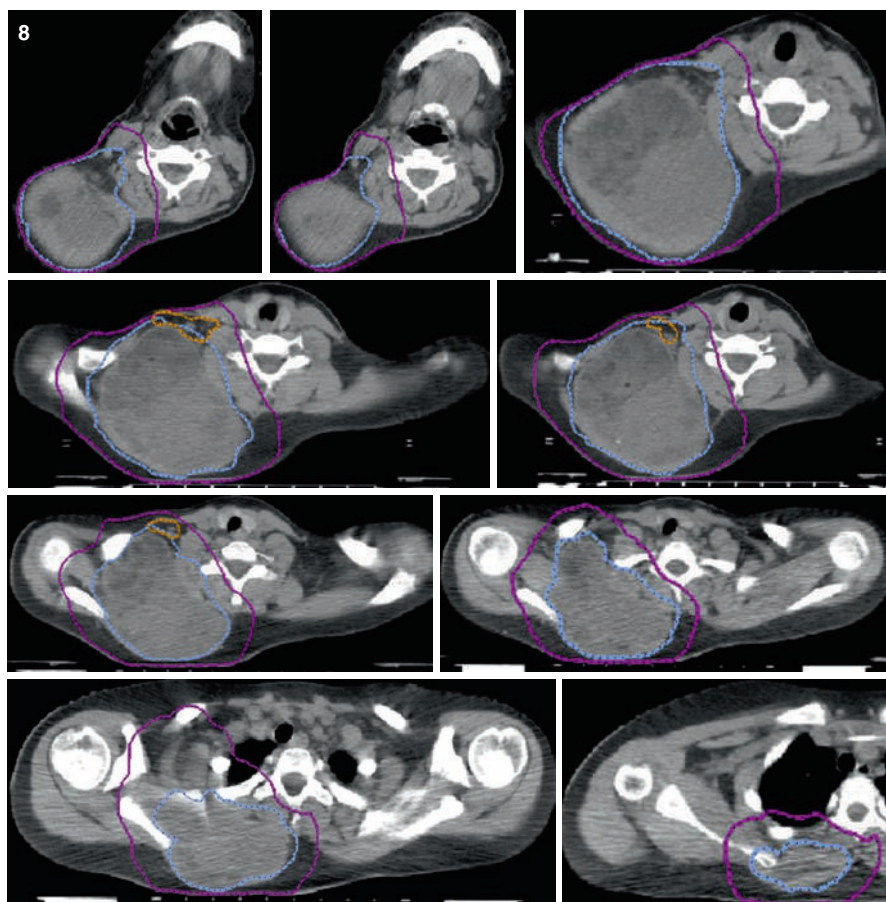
Contouring the GTV (*blue*). The shoulder girdle is one of the most difficult parts of the body to immobilize and accurately recreate daily due to the clavicular, humeral, and scapular articulation. A long mask with Aquaplast was used to immobilize the shoulder while maintaining head and neck alignment. The diagnostic MRI was reformatted to the RTP-CT to align to the spine, brachial plexus, and shoulder joint and helped delineate normal tissues from the tumor. MRI in the treatment position would be an ideal method to delineate the GTV with respect to normal tissues. The exiting nerve roots of the brachial plexus (*gold*) about the anterior aspect of the mass adjacent to the cervical spine. These nerve roots are best visualized on MRI and contoured as an OAR. The blue arrows show the trajectory of the nerve as it exits the spine and tracts between the anterior scalene and middle scalene muscle. The RTOG brachial plexus contouring atlas is used to contour the brachial plexus [10]
